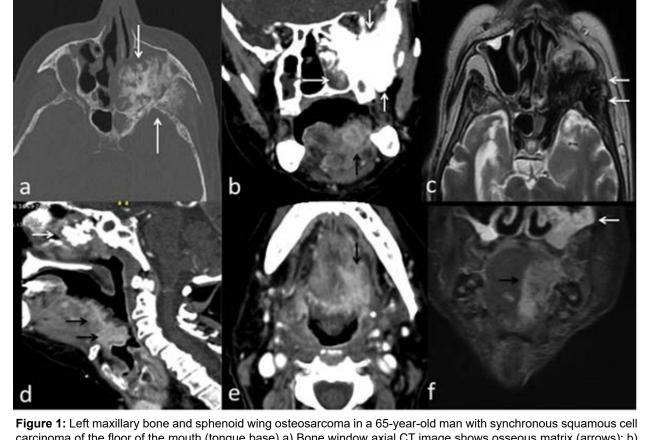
Left maxiliary bone and sphenoid wing osteosarcoma in a 65-year-old man with synchronous squamous cell carcinoma of the floor of the mouth (tongue base) a) Bone window axial CT image shows osseous matrix (arrows); b) Soft tissue component of the mass (long arrow); c) T2-weighted axial MR image shows signal void areas of osseous matrix (arrows); d) Sagittal contrast enhanced CT image shows maxillary tumor (white arrow) and synchronous oropharyngeal mass (black arrows) in the same plane; e) Contrast enhanced axial CT; f) Coronal contrast-enhanced T1-weighted MR images show the extension of oropharyngeal mass to the floor of mouth (tongue base) (black arrow) and MRI shows maxillary mass (white arrow).
